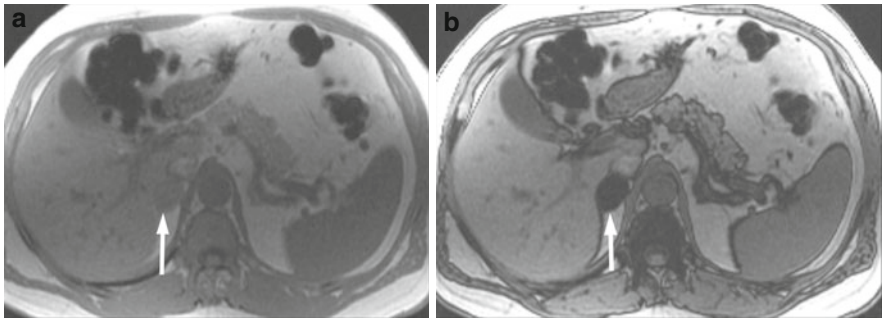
Adrenal adenoma. (a) Right adrenal mass (*arrow*) is seen on this in-phase (MRI). (b) There is a significant decrease in signal on the out-of-phase MRI
